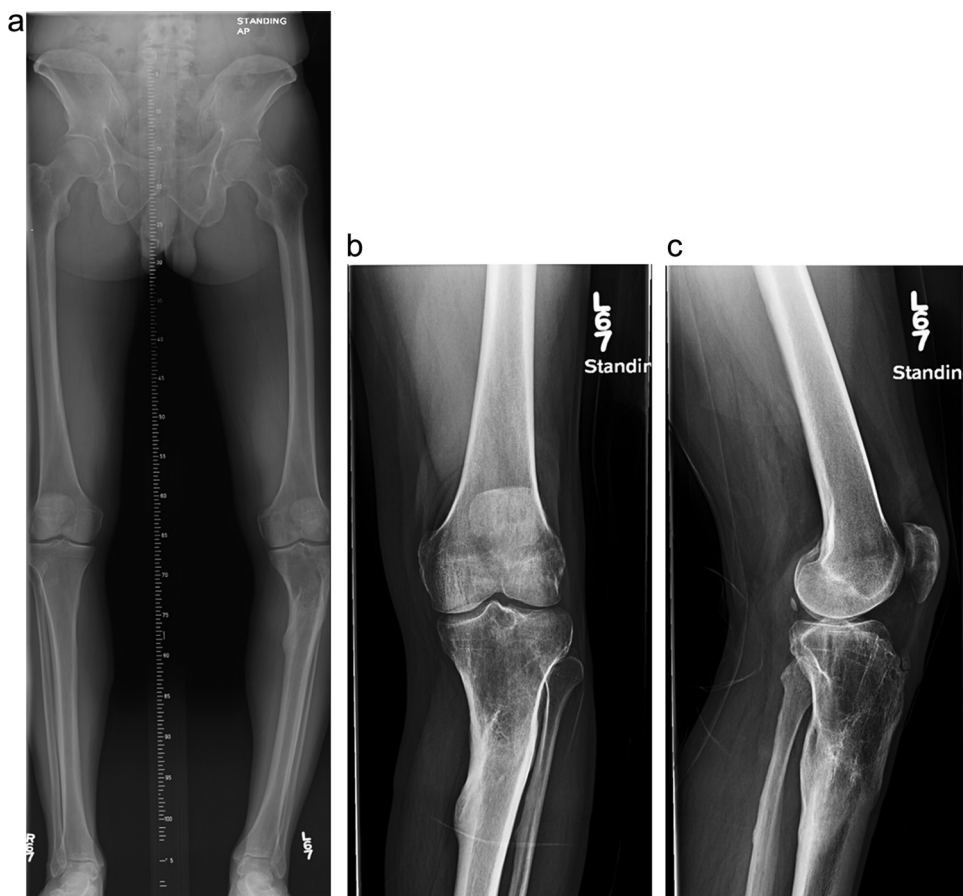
(A) Pre-operative scanogram demonstrating 15 degree varus deformity. (B and C) Pre-operative AP and lateral knee radiographs again demonstrating varus deformity.
